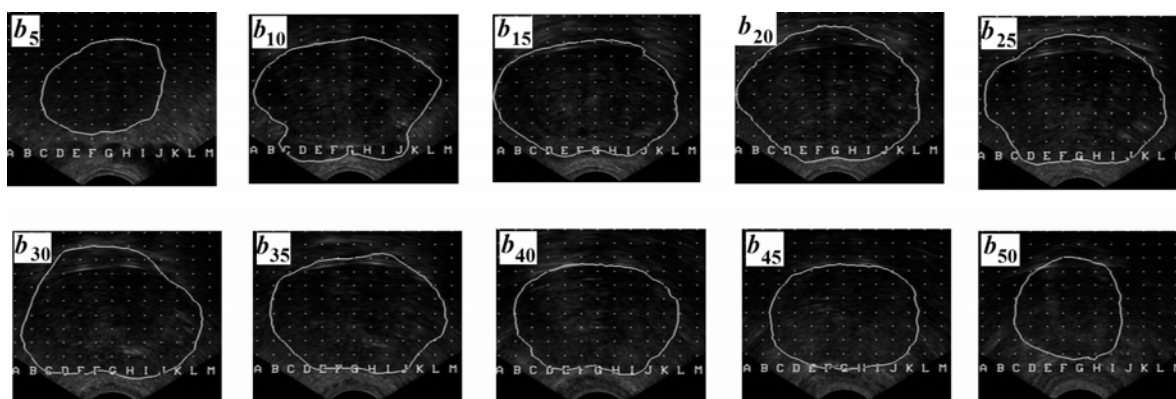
Two-dimensional transrectal ultrasound (2D-TRUS) axial images of prostate, from the prostate base (b_0) to the prostate apex (b_{50}). The cross-sectional area of the prostate capsule (A) from phase I brachytherapy in one patient; b_5 ($A = 9.9 \cdot 10^{-4} \text{ m}^2$), b_{10} ($A = 10.5 \cdot 10^{-4} \text{ m}^2$), b_{15} ($A = 19.8 \cdot 10^{-4} \text{ m}^2$), b_{20} ($A = 20.9 \cdot 10^{-4} \text{ m}^2$), b_{25} ($A = 20.1 \cdot 10^{-4} \text{ m}^2$), b_{30} ($A = 20.3 \cdot 10^{-4} \text{ m}^2$), b_{35} ($A = 18.3 \cdot 10^{-4} \text{ m}^2$), b_{40} ($A = 15.6 \cdot 10^{-4} \text{ m}^2$), b_{45} ($A = 14.5 \cdot 10^{-4} \text{ m}^2$), b_{50} ($A = 10.1 \cdot 10^{-4} \text{ m}^2$).
